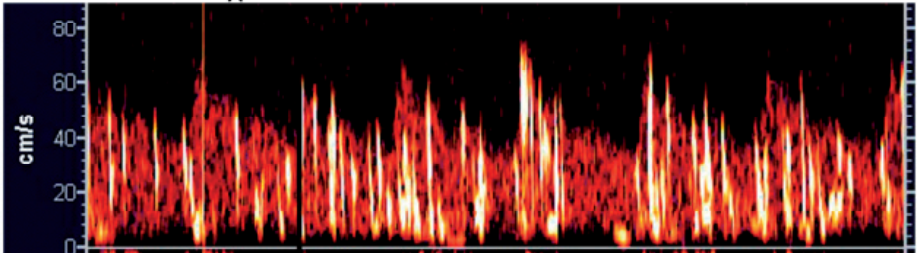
Examples of the 3 types of showers in the velocity spectrum of the Transcranial Doppler (TCD) screen.
